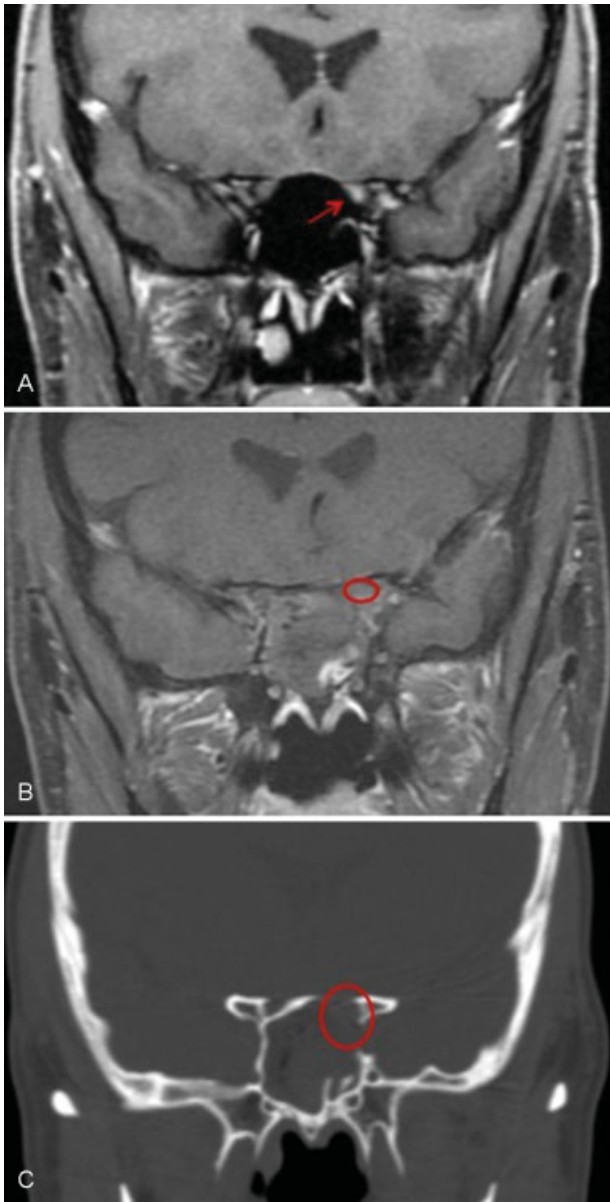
Pre- and postoperative MRI. (A) Preoperative coronal MRI T1 weighted with contrast demonstrates a small intra canalicular lesion inferomedial to the left optic nerve. (B) Postoperative coronal MRI T1 weighted with contrast demonstrates gross total resection. (C) Postoperative coronal CT demonstrating decompression of the optic canal. Arrow, tumor; circle, optic nerve/canal.
